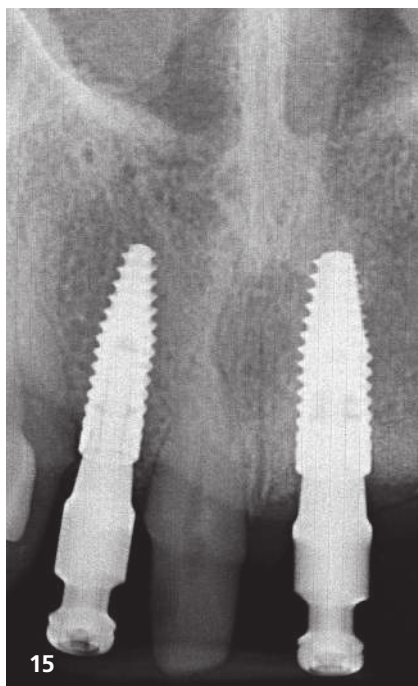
Successful soft-tissue healing observed at the seven-month follow-up. – Fig. 13: Placement of the final restorations. – Fig. 14: The aesthetically pleasing appearance of the final crowns. – Fig. 15: Radiographic assessment at the time of final impression confirmed precise implant placement and verified bone structure integrity.
